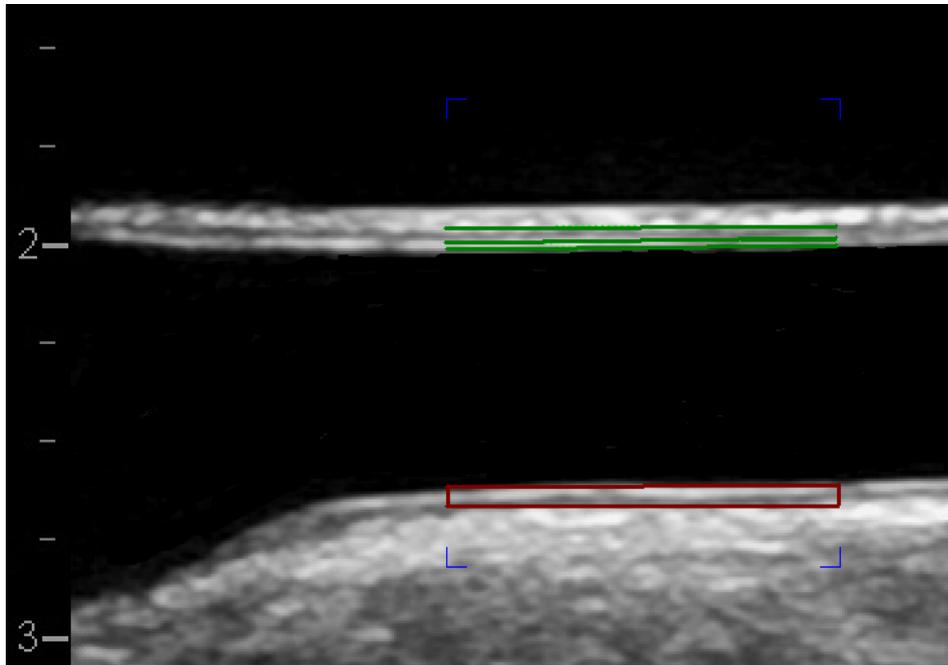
2D image of the right common carotid artery obtained by ultrasound. Black color represents the blood. The red box in the far wall represents the IMT. The blue lines indicate the length of the region of interest (10 mm) and the green lines the intima–media in the near wall (not used in our studies).
